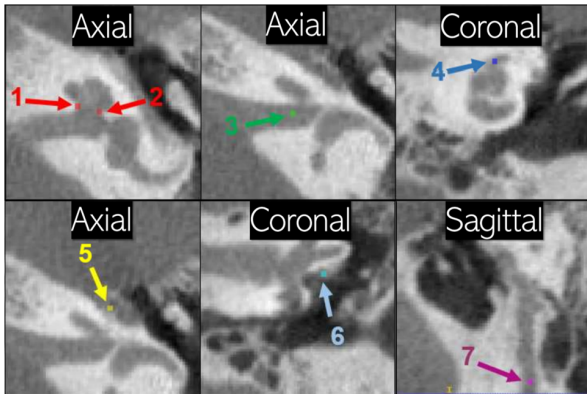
Landmarks' location in a sample CT scan from [10]
